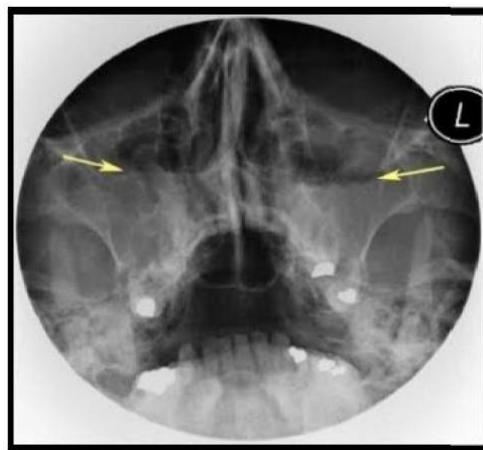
X-RayPNS (Water's view) showing air fluid level in bot maxillary sinuses.
